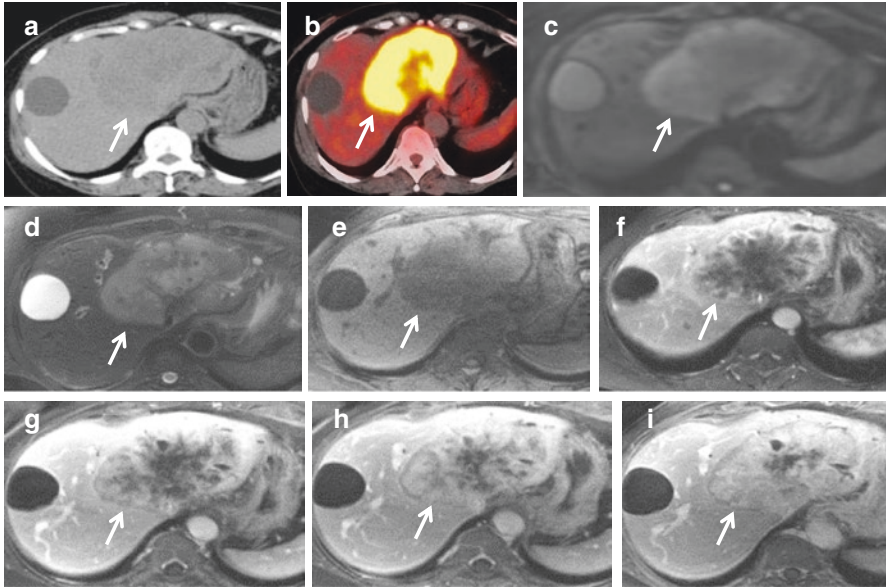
Large mass-forming intrahepatic cholangiocarcinoma (iCCA) CT, 18F-FDG PET, and MRI. The mass is (a) isodense with areas of central hypodensity on noncontrast CT (white arrow). (b) Axial ^{18}F -FDG-PET/CT show heterogeneous hypermetabolism in the periphery of the hepatic mass (white arrow). The mass shows (c) DWI hyperintensity (white arrow), (d) heterogenous T2-weighted hyperintensity, (e) T1-weighted hypointensity, (f) peripheral arterial phase hyperenhancement (white arrow), and (g–i) progressive centripetal enhancement on portal venous and delayed phases (white arrow). ^{18}F -FDG 8F-fluorodeoxyglucose, PET positron emission tomography, CT computed tomography, MRI magnetic resonance imaging, DWI diffusion-weighted imaging
